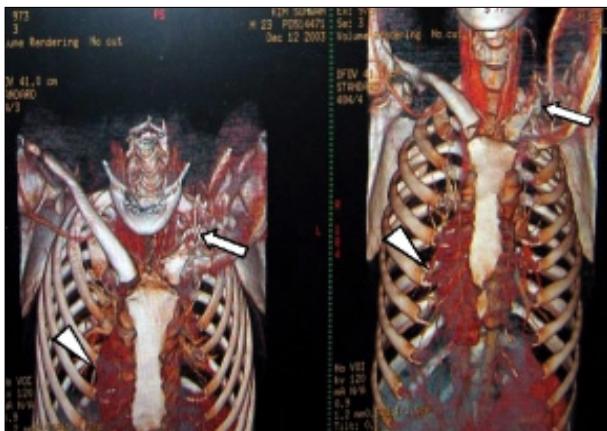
The 3D-Chest CT: the apical lordotic and AP views, showing congenital pseudoarthrosis of the left clavicle. The distal 3/4 of the left clavicle is absent (arrow) and mesocardia is shown (arrow head).
